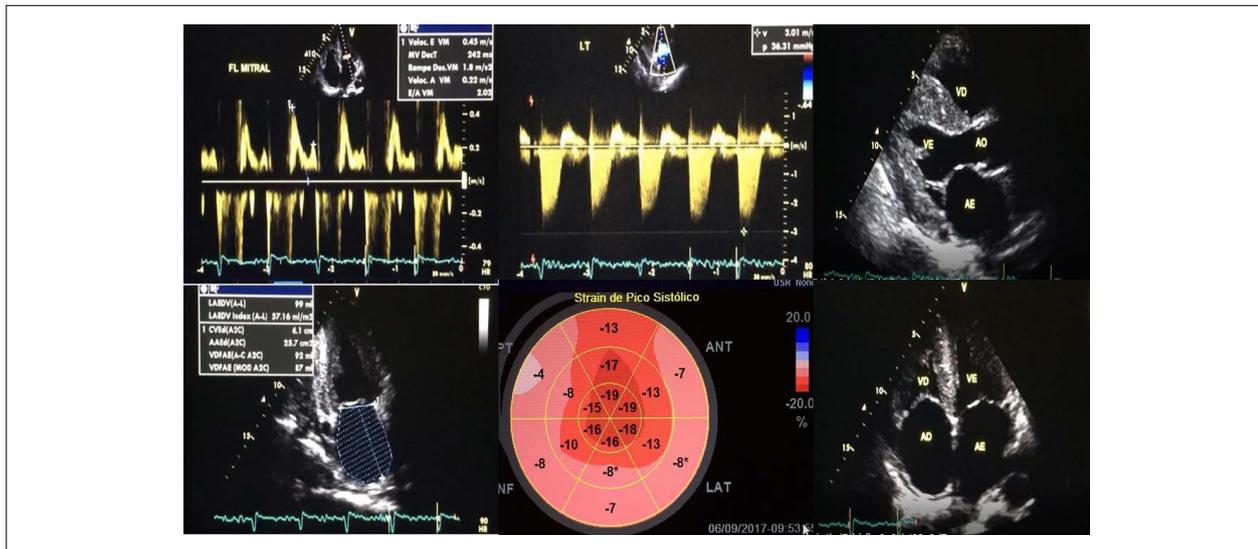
Transthoracic echocardiogram showing pseudonormal mitral Doppler pattern (type II diastolic dysfunction), tricuspid regurgitation peak velocity >2.8 m/s and biatrial enlargement with indexed LA volume of 87 mL/m². Parasternal longitudinal apical-4 chamber projections showing increased myocardial brightness, interatrial septum and valve thickening, and LVH. Global Longitudinal Strain showing typical amyloidosis pattern – “relative preservation of the apical regions” and longitudinal strain reduction in the basal and middle myocardial segments.
